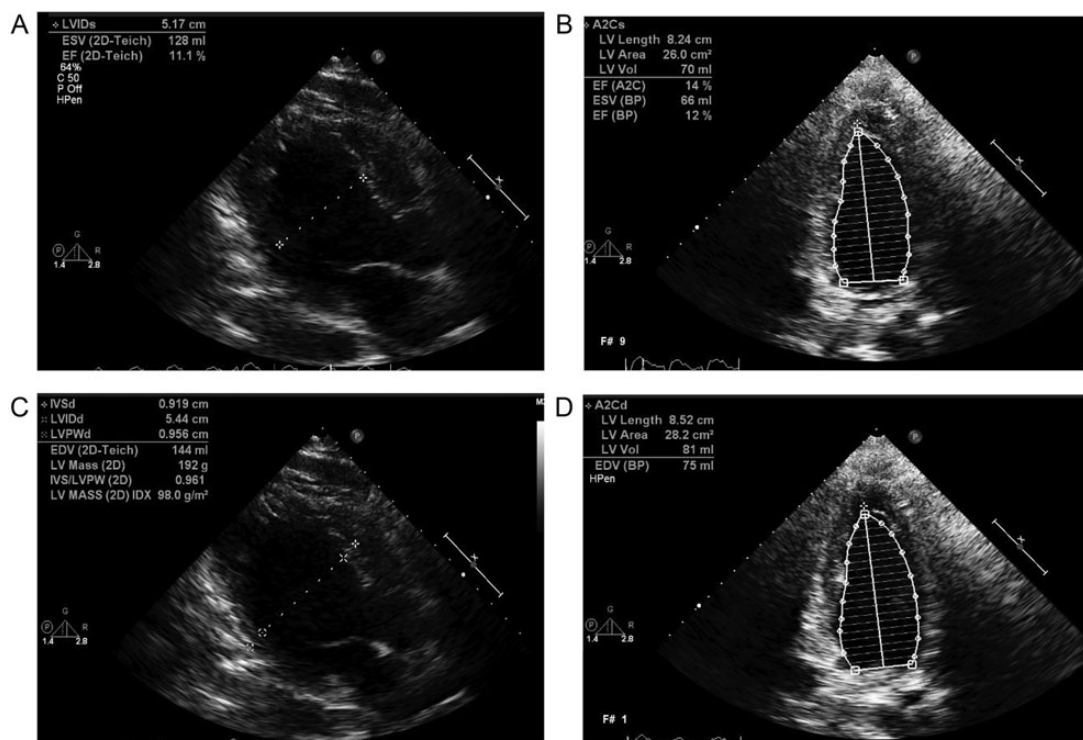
Echocardiographic parasternal long-axis view and two-chamber view of the patient's heart in systole (A and B, respectively) and in diastole (C and D, respectively).
